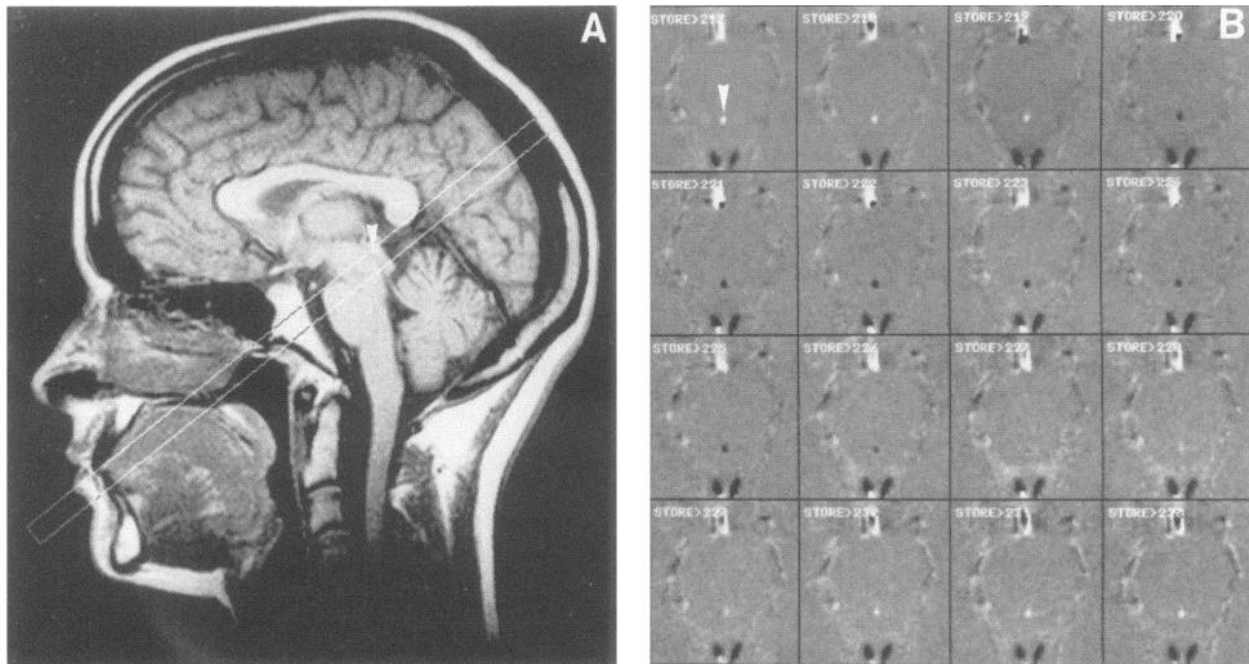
A: Magnetic resonance image in the midsagittal plane of a healthy volunteer. Area within the box was divided into 3 8-mm-thick sections perpendicular to the cerebral aqueduct (arrowhead). After inspection of the 3 sections, the subject was repositioned, if required, and flow measurement was started. B: flow phase images of the cerebral aqueduct (arrowhead), showing a sequence of images covering ~ 1.3 heart cycles. The difference between aqueduct and brain tissue phase signal is proportional to the velocity of the CSF, while the direction of the flow can be seen as either a lighter (cranial flow) or darker aqueduct (caudal flow).
